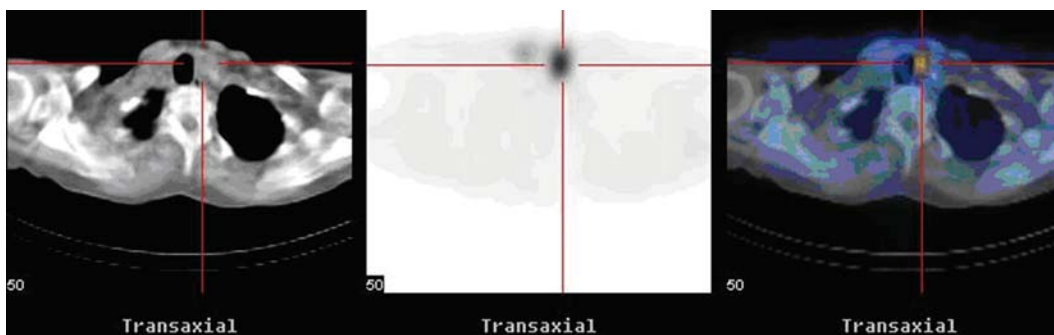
MIBI/CT fusion image of a parathyroid adenoma medial to the left thyroid lobe.
